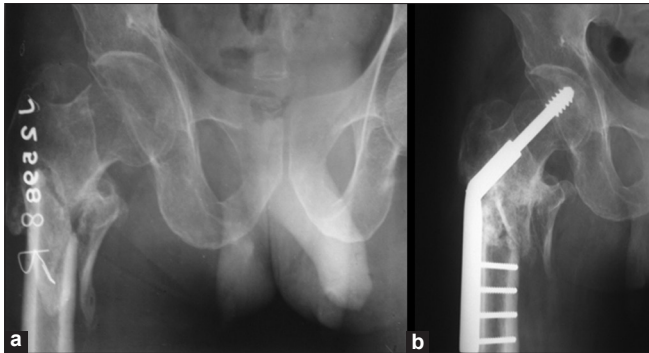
X-ray right hip anteroposterior view (a) 4 months after injury showing sclerotic margins. (b) Follow-up X-ray after 1 year showing DHS in situ and union at the fracture site
